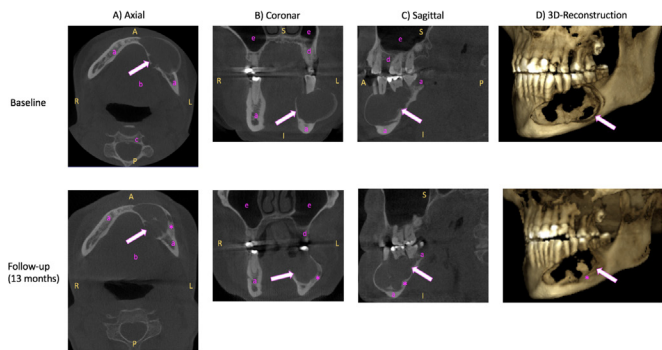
Three-dimensional (3D) cone-beam computed tomography (CBCT) of the mandible. (A) Axial, (B) coronal, (C) sagittal view and (D) 3D reconstruction of unenhanced CBCT images of the ameloblastoma (arrow) in the left mandible at baseline (2 years before surgery, upper line) and at follow-up 1.5 years after the baseline examination (lower line). Baseline (upper row): Ameloblastoma (arrow) appears as roundish, sharply defined hypodense lump. Follow-up (lower line): Compared with baseline, the ameloblastoma (arrow) appears more sclerosed (asterisk) at the edges with relative size constancy. R, right; L, left; A, anterior; P, posterior; S, superior; I, inferior; a, mandible; b, floor of the mouth; c, vertebral body; d, maxilla; e, sinus maxillaris.
